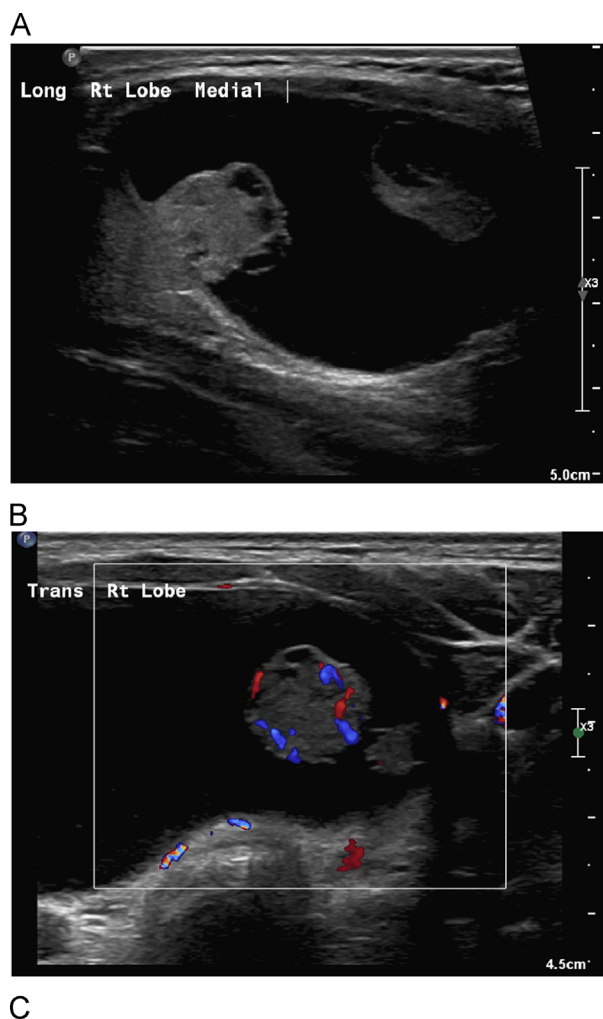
Autonomously functioning nodule(s). A 15-year-old girl presented with hyperthyroidism and a suppressed TSH. Thyroid US revealed a large cystic and solid mass, measuring $5.7 \times 5.6 \times 3.3$ cm, in the right lobe (A). The predominantly cystic mass had several peripheral nodular solid components that were hyperemic on Doppler image (B). (C) I-123 thyroid scan was performed and showed that three of the solid nodules comprising the complex mass accumulated the radiotracer with suppression of the remainder of the gland; 5- and 24-hour uptake were 15% and 25%, respectively (not shown). The patient underwent right hemithyroidectomy and pathology was consistent with follicular adenoma with hemorrhagic cystic degeneration. No DTC was revealed at pathology. Up to 30% of children may have an incidentally discovered DTC associated with an autonomously functioning nodule, as opposed to 3% of adults. Consequently, lobectomy and isthmusectomy are the recommended management for pediatric patients with autonomously functioning thyroid nodules.
